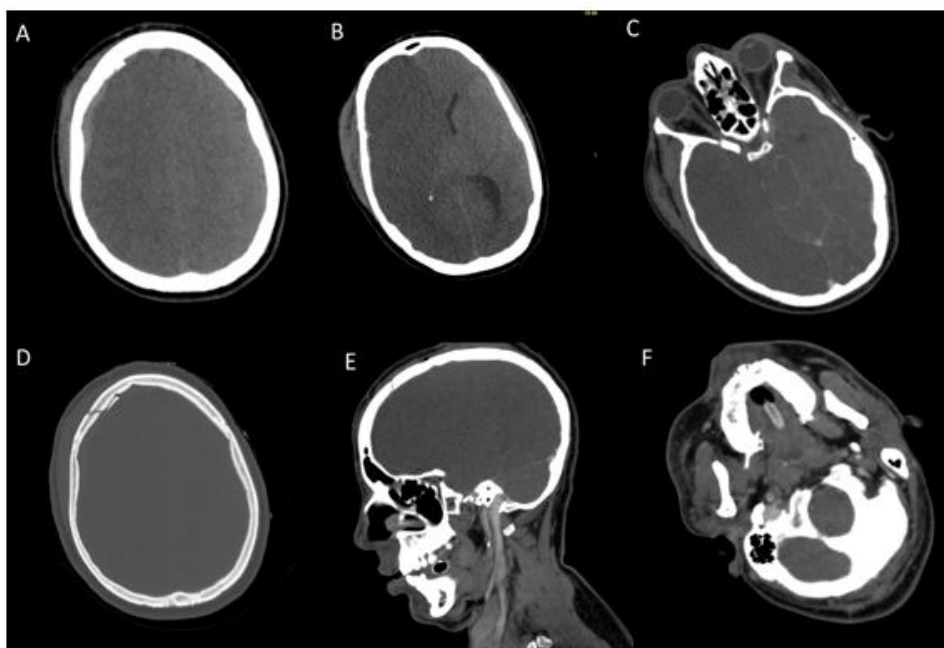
Brain CT scan before contrast injection (A, B, C): parenchymal window: Axial section (A, B, C) showing a right frontal extradural hematoma associated to a right hemispheric hypodensity exerting a mass effect on the median structures with contralateral diffuse edema and an anteroposterior elongation of the mesencephalon related to a central herniation. Bone window axial section (D) showing a right frontal fracture line. Parenchymal window, after contrast injection sagittal (E) and axial section (F): showing a linear endoluminal hypodensity of the right internal carotid artery likely related to a carotid dissection.
